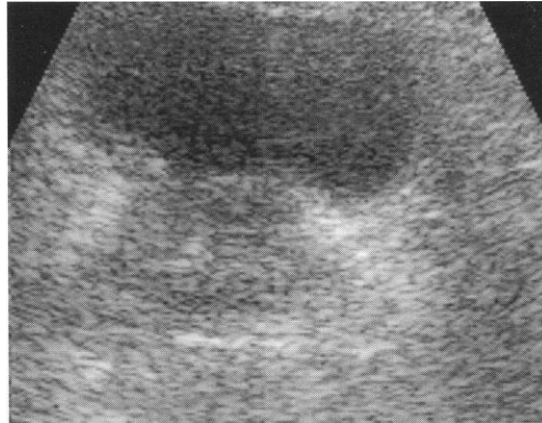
Speckle in an ultrasound image of the prostate (Birkfellner, 2014)
